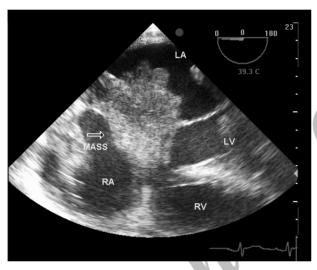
Transesophageal echocardiographic view of the mass (arrow) with involvement of interatrial septum
